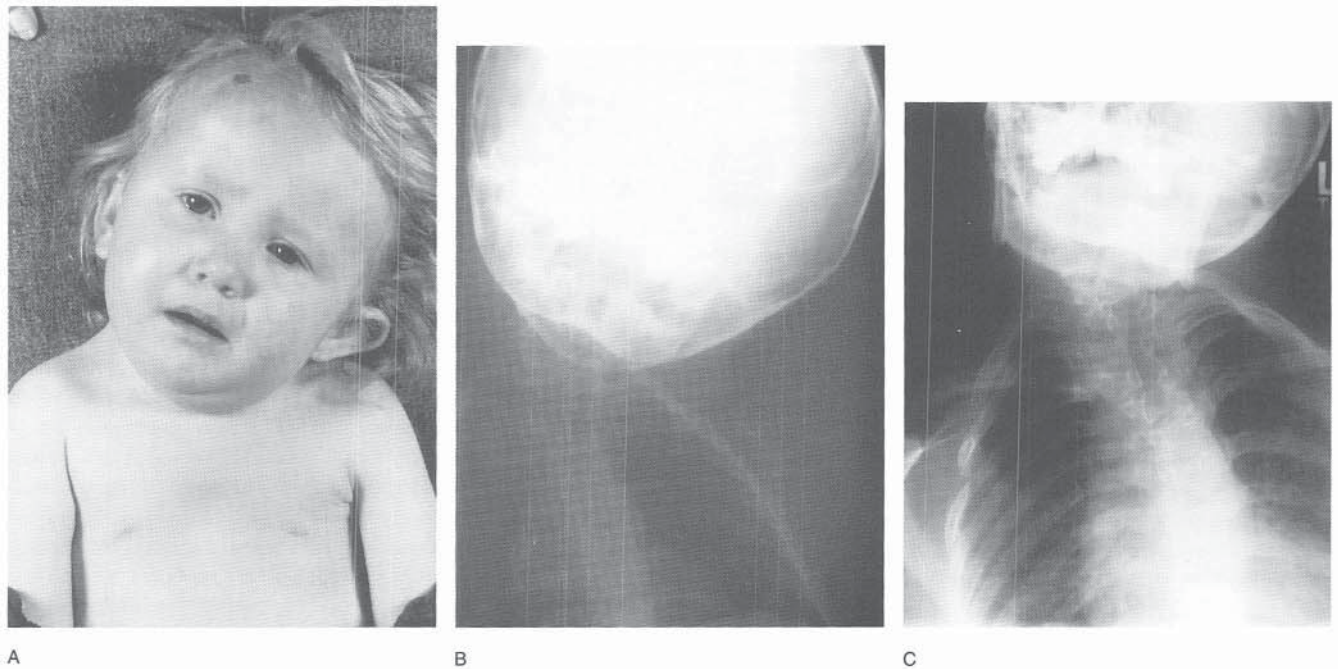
A and B, Clinical and radiographic appearance of a 2-year-old girl with Klippel-Feil syndrome and congenital cervicothoracic scoliosis due to numerous vertebral abnormalities. C, Eleven years later, without operative intervention, the curve was of similar size, and the head tilt was mild in its clinical appearance. Neurologic findings were normal.
